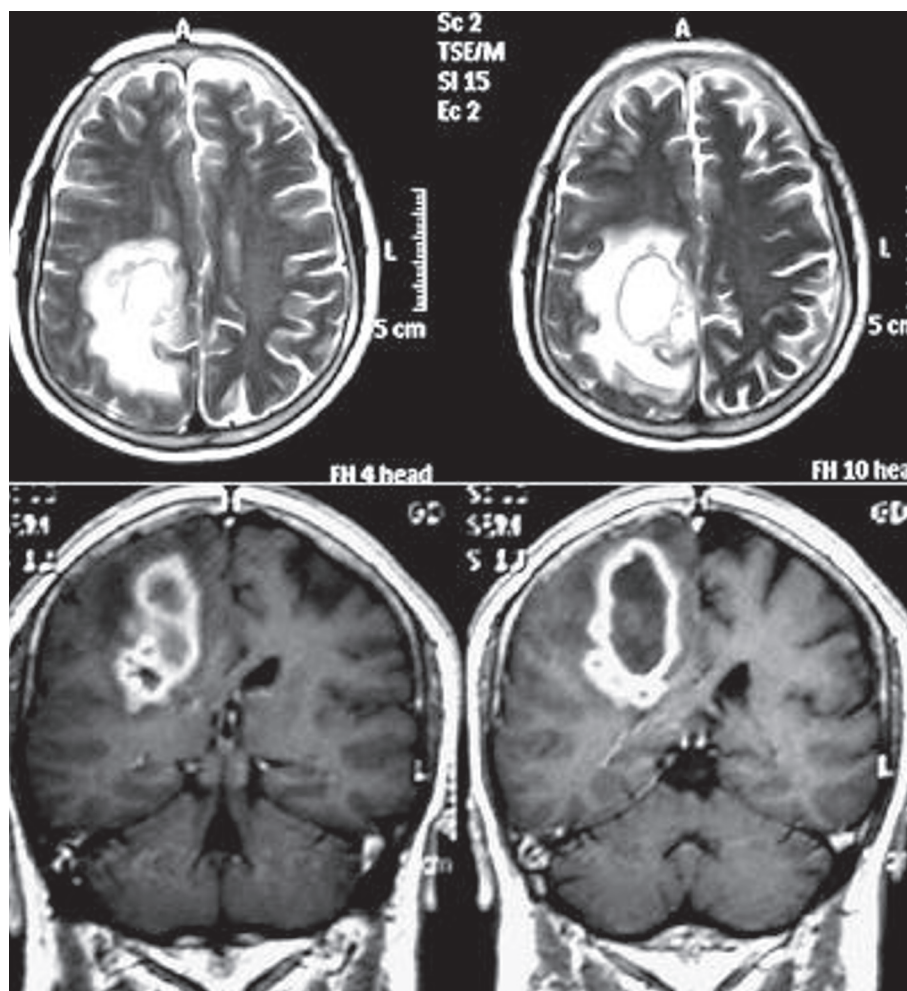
Axial T2-weighted brain MRI demonstrating a large mass in the frontoparietal area compressing the lateral ventricle. On coronal T1-weighted MRIs with contrast, rim enhancement is seen
